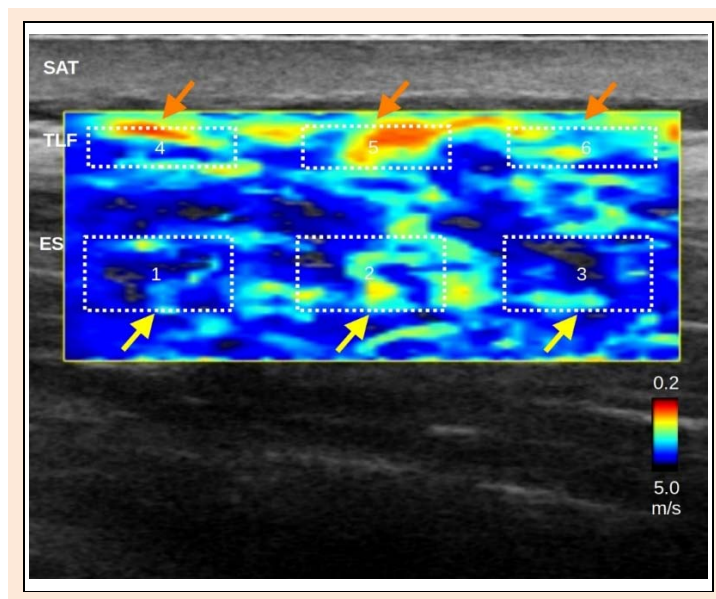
Ultrasound elastography. Measurements were performed in equidistant rectangular areas within the thoracolumbar fascia (orange arrows) and the erector spinae muscle (yellow arrows). SAT, subcutaneous adipose tissue; ECT, extramuscular connective tissue; ES, erector spinae muscle.
